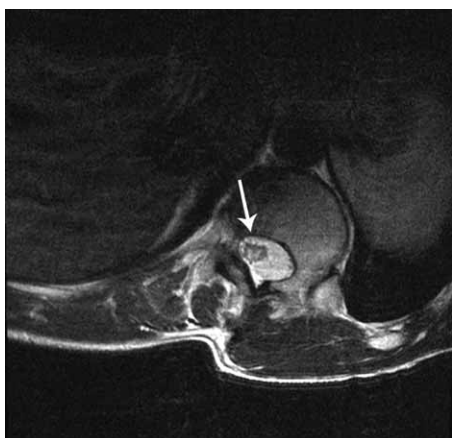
Axial MRI in T2-weighted images shows atrophic thoracic spinal cord with intramedullary lesion within the conus medullaris restricted to the gray matter, consistent to the subacute myelopathy or Foix-Alajouanine syndrome (2006).
